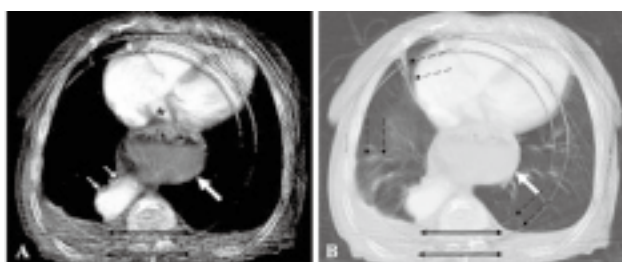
Axial CT of the thorax; mediastinal (A) and parenchymal (B) window showing a large mixed type hiatal hernia (arrows) compressing the left atrium (*), bilateral pleural effusion (double arrows), Kerley B lines (dashed arrows), elongated and tortuous aorta (small arrows).
